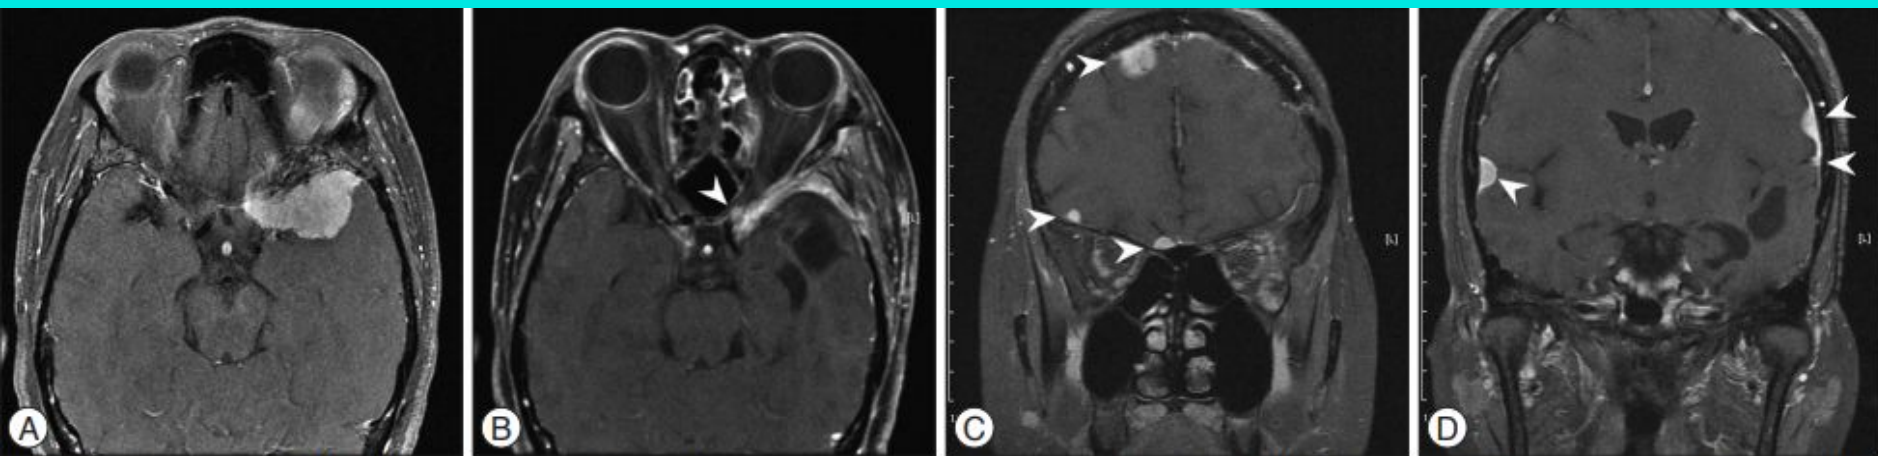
A : Preoperative MRI displaying a left sphenoidal ridge meningioma. B : Four months later, MRI showing the local recurrence (arrowhead). C and D : Approximately 18 months later, MRI revealing multiple meningiomas around bilateral convexity (arrowheads).
